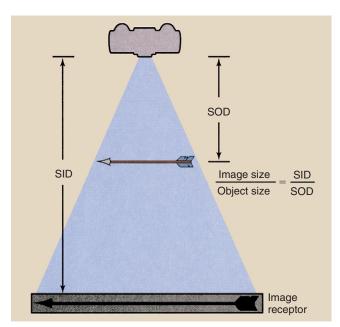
Principle of magnification radiography. The magnification factor is equal to the ratio of image size to object size.
